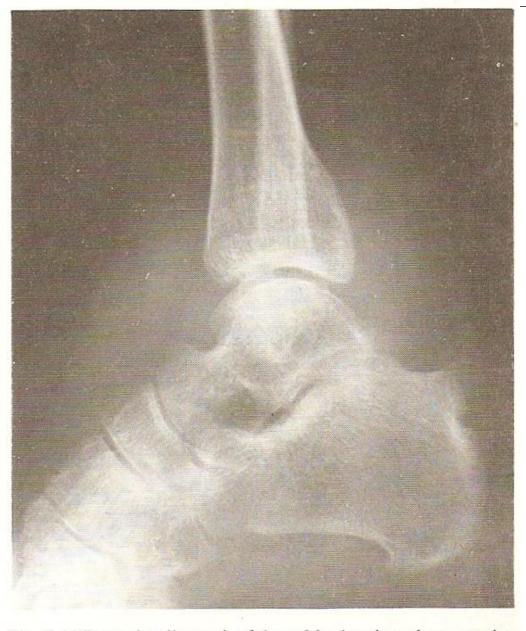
Lateral radiograph of the ankle showing a bone erosion in the region of the Achilles bursa, periosteal calcification at the calcaneal attachment of the plantar fascia and obliteration of the calcaneo-talar joint.
